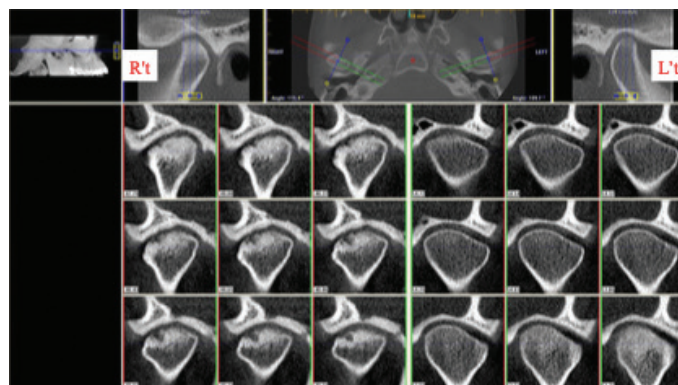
Osteoarthritic changes of the TMJ on CBCT showed the coronal view of right condyle with erosion, concavity and subchondral cyst formation; loss of continuity of the articular cortical bone and mild sclerosis of left condyle
